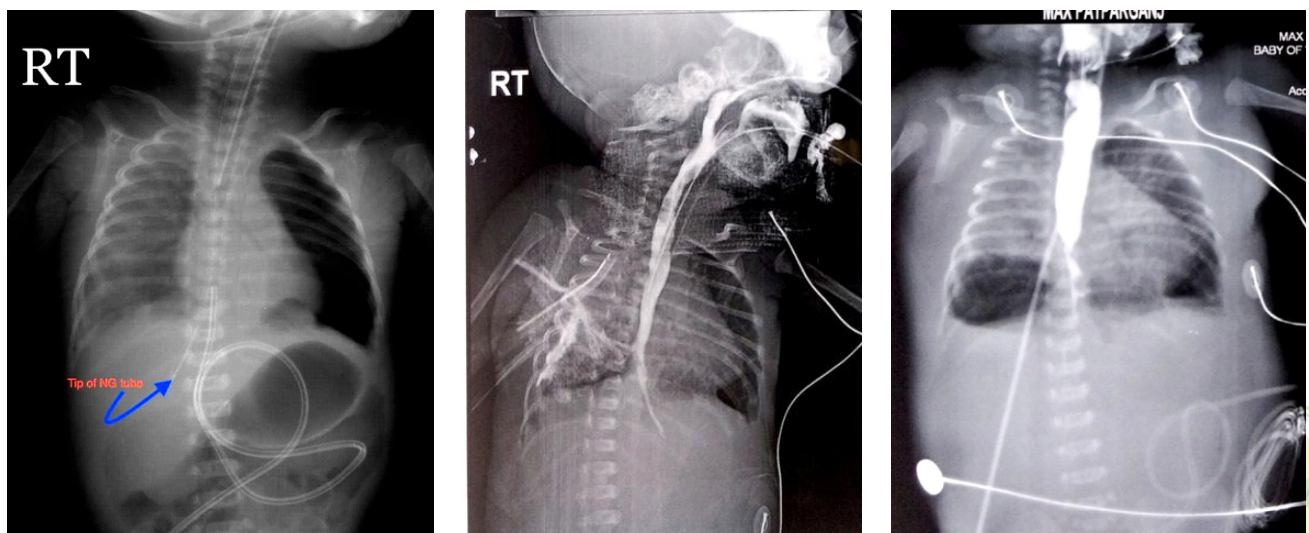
A) X-ray showing pneumothorax on left side. Note the position of NG tube (it is going towards right side).
